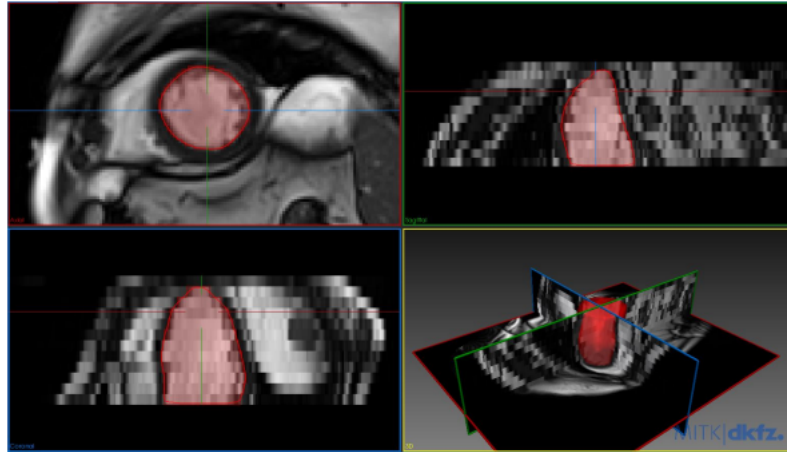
Example of segmented endocardial closed surface in two different MRI slices (taken from [115]). Top left is the axial view, top right is the sagittal view, bottom left is the coronal view and bottom right is the 3D view.
